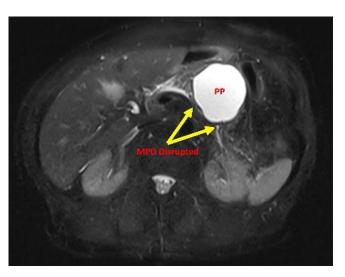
MRI showing MPD rupture and relapsed PP with communication with the MPD. MRI: magnetic resonance imaging; MPD: main pancreatic duct; PP: pancreatic pseudocyst.
